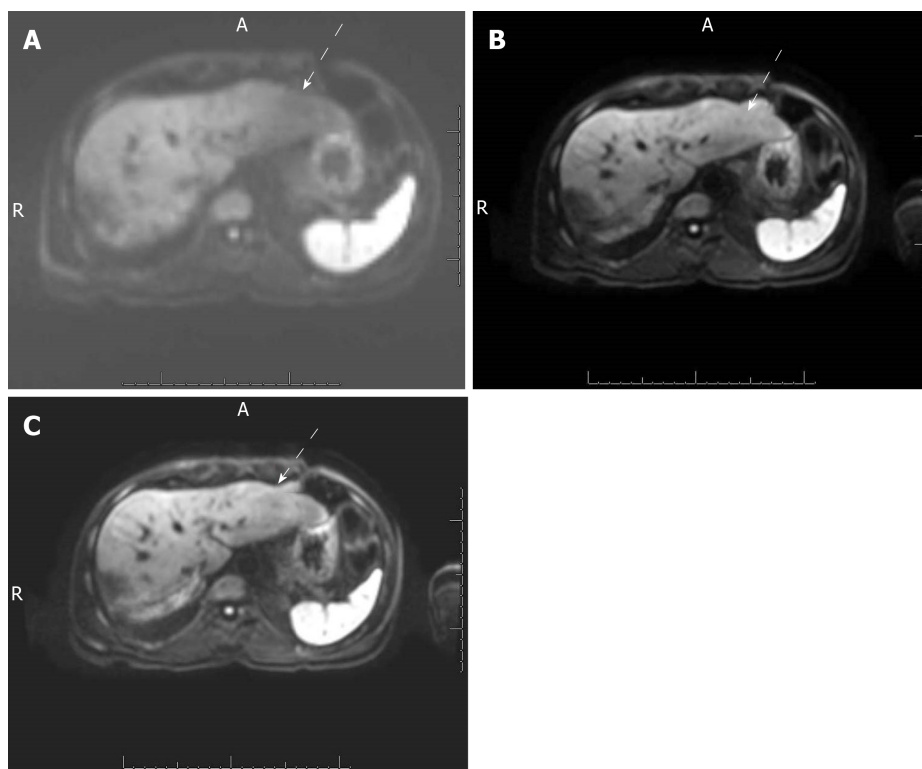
Axial diffusion-weighted images of the liver of a 61-year-old man with a history of hepatocellular carcinoma. The images were obtained with (A) free-breathing diffusion-weighted imaging (DWI), (B) simultaneous multislice DWI and (C) prospective acquisition correction DWI. The qualitative image quality scores of these series were 3, 5 and 5, respectively. Free-breathing DWI demonstrated artifacts on the left liver, seen as signal loss on the left liver compared to the right liver, (white arrows) that were absent on the other 2 sequences.
